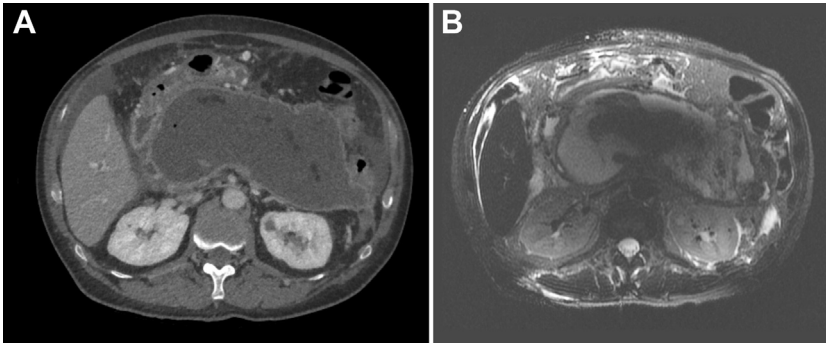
Necrotizing pancreatitis CT versus MRI. Comparison of (A) computed tomography imaging, in contrast to (B) MRI. The MRI T2 weighted phase is the best modality for visualizing the heterogeneity of solid debris and liquid necrosis present in walled-off pancreatic necrosis.
